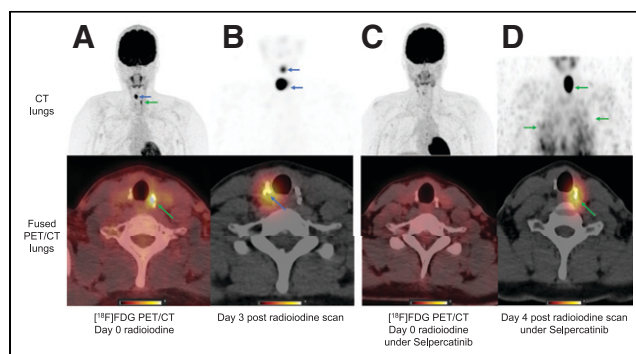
During first radioiodine treatment, [^{18}F]FDG PET/CT scan showed hypermetabolism in left cervical region due to tumor residue (green arrows) (A), and postradioiodine scan revealed right laterocervical (blue arrows) fixations with no uptake at tumor site (B). During second radioiodine treatment with selpercatinib, [^{18}F]FDG PET/CT scan (C) and postradioiodine (D) scan showed [^{18}F]FDG-negative, radioiodine-positive neck residue and metastatic miliary lung disease (green arrows).
